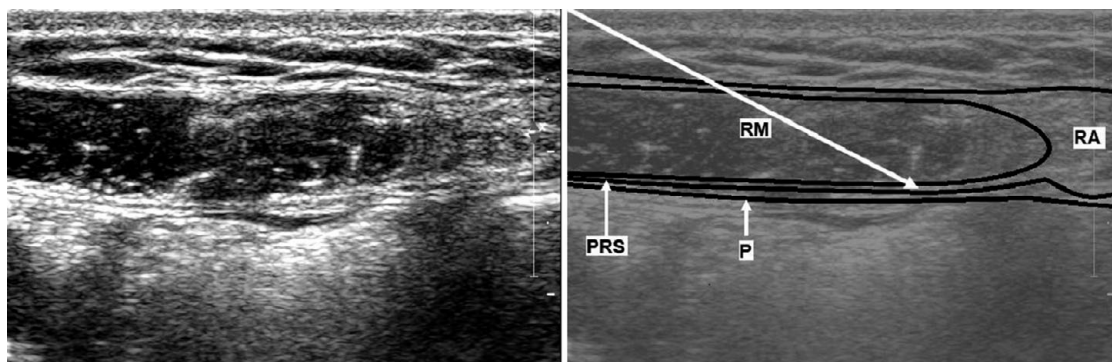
Ultrasound appearance of the rectus muscle (RM), posterior rectus sheath (PRS), peritoneum (P) and linea alba of the rectus abdominis (RA).
